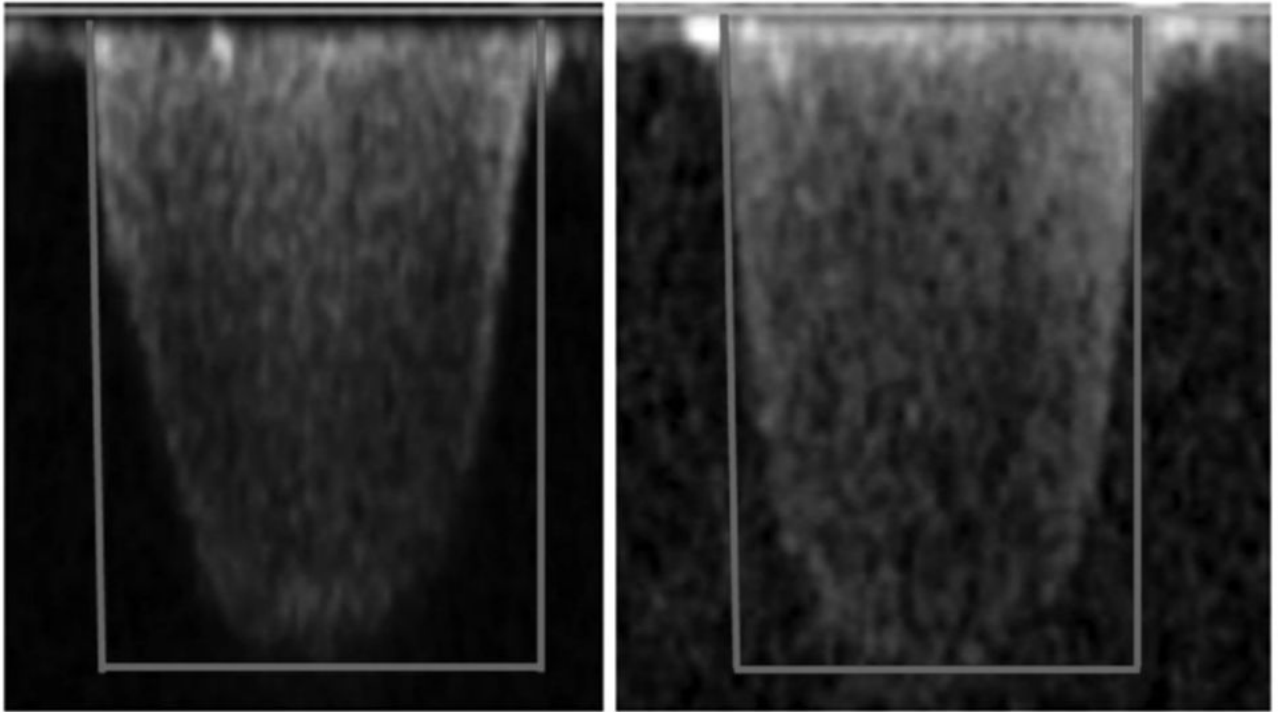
Continuous-wave Doppler regurgitant jet in a patient before CRT (right) and after CRT (left). Estimated closing pressure ratio increases from 0.682 to 0.894.
